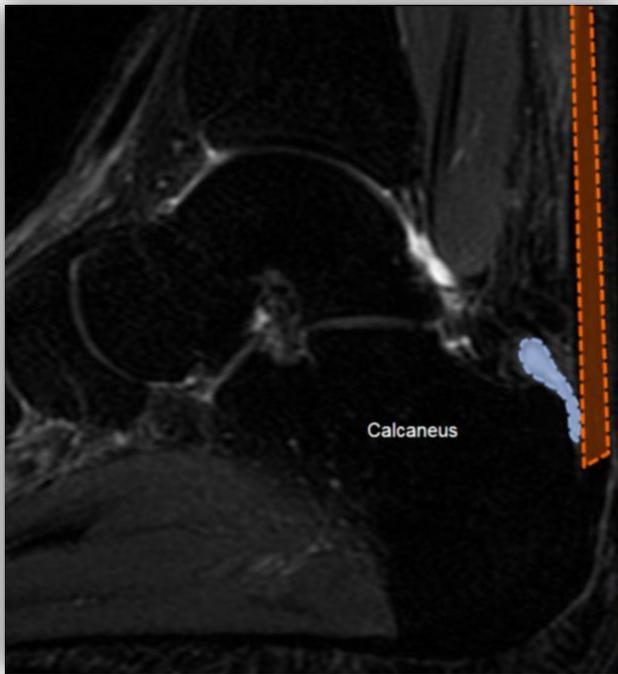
Retrocalcaneal bursa anatomy. Sagittal T2 weighted fat-suppressed MR image demonstrates distension of the bursa (blue dashed outline), which is located between the Achilles tendon (orange dashed outline) and calcaneus, in a patient with bursitis.
